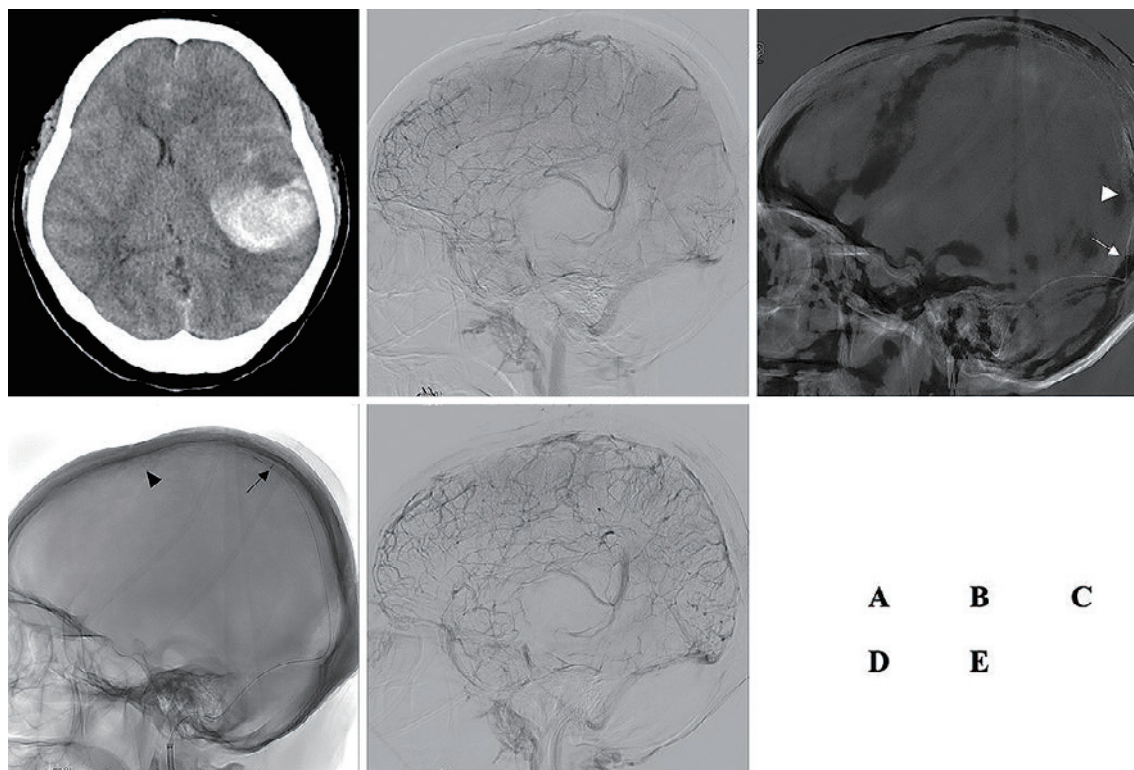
Treatment of case 2. A. Pre-treatment plain CT showed a massive hematoma within the left temporal lobe causing a midline shift. B–E. Angiography during thrombectomy. B. Pre-treatment left carotid angiography reveals occlusion of the SSS partially straight sinus. C. A stent retriever is deployed in the proximal thrombosed segment of the SSS (arrowhead), and an aspiration catheter is positioned in the confluence (arrow). D. The stent retriever and aspiration catheter are advanced into the middle of the SSS. E. Final angiography reveals the recanalization of the posterior two-thirds of the SSS and antegrade venous flow of the SSS. CT: computed tomography; SSS: superior sagittal sinus.
